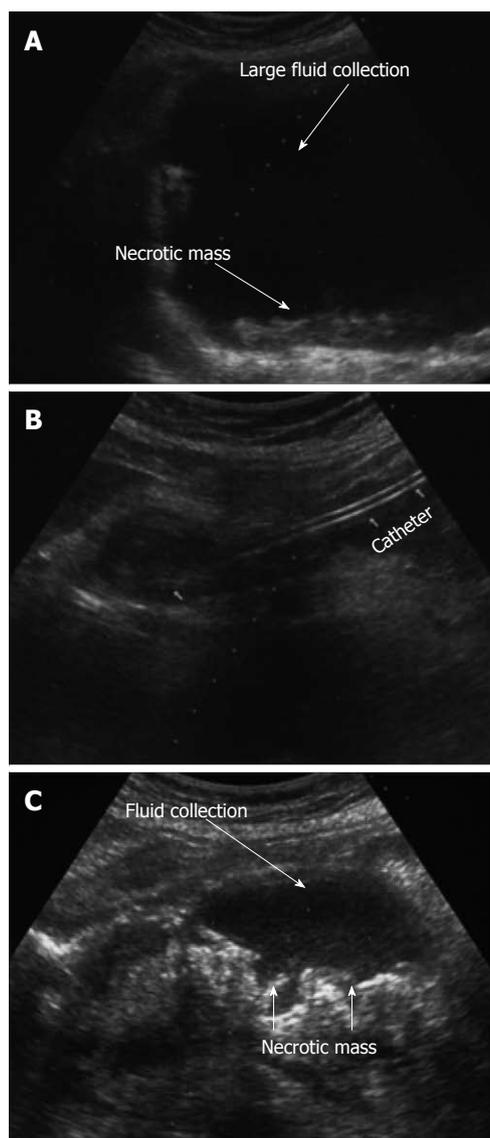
Ultrasound appearance of pancreatic necroses and a large acute fluid collection before and after drainage. A: Large fluid collection and pancreatic necroses before drainage; B: Catheter in the peripancreatic fluid collection; C: Massive pancreatic necroses with secondary fluid collection.
